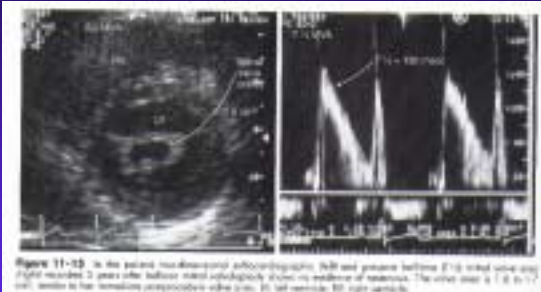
In the parasternal short-axis echocardiographic (left) and parasternal long-axis (right) views 2 years after balloon mitral valvuloplasty, there is evidence of mitral regurgitation. The color scale is 1.0 to 1.7 m/s, sensitive for mitral regurgitation color scale. RV, right ventricle; LA, left atrium; LV, left ventricle.
